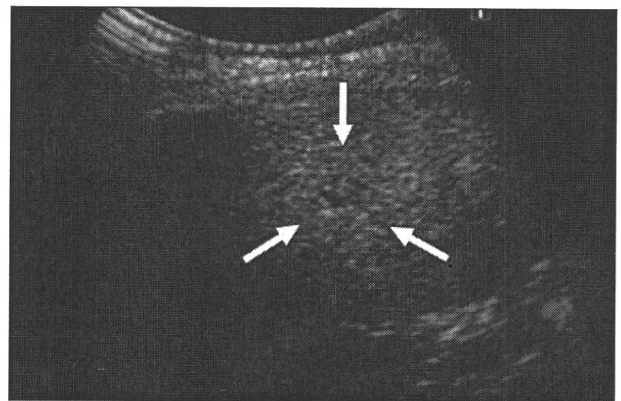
62-year-old man with hepatitis B-related cirrhosis. A, Unenhanced sonogram shows hypoechoic 17.1-mm-diameter lesion (arrows) in liver. B, Contrast-enhanced sonogram at peak enhancement (31 seconds after injection) shows hyperenhancing lesion (arrows). C, Contrast-enhanced sonogram obtained in 1-minute phase (56 seconds after agent injection) shows hypoenhancing lesion (arrows), which was diagnosed as poorly differentiated hepatocellular carcinoma after ultrasound-guided needle biopsy.
